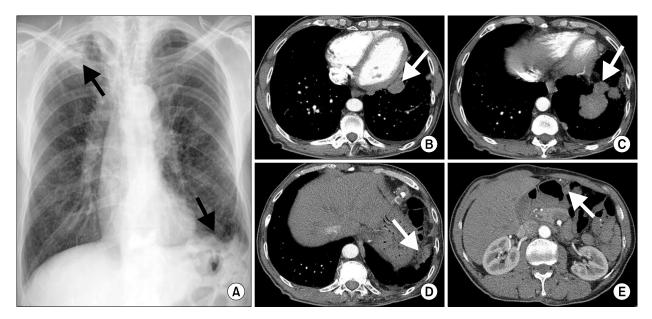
(A) Chest X-ray showing a left diaphragmatic mass with irregular margin and consolidation in the right upper lobe. (B-E) Chest computed tomography. Multiple lobulated masses and nodules present along the left lower media-stinum (B), left diaphragm (C, D), and omentum (E).
